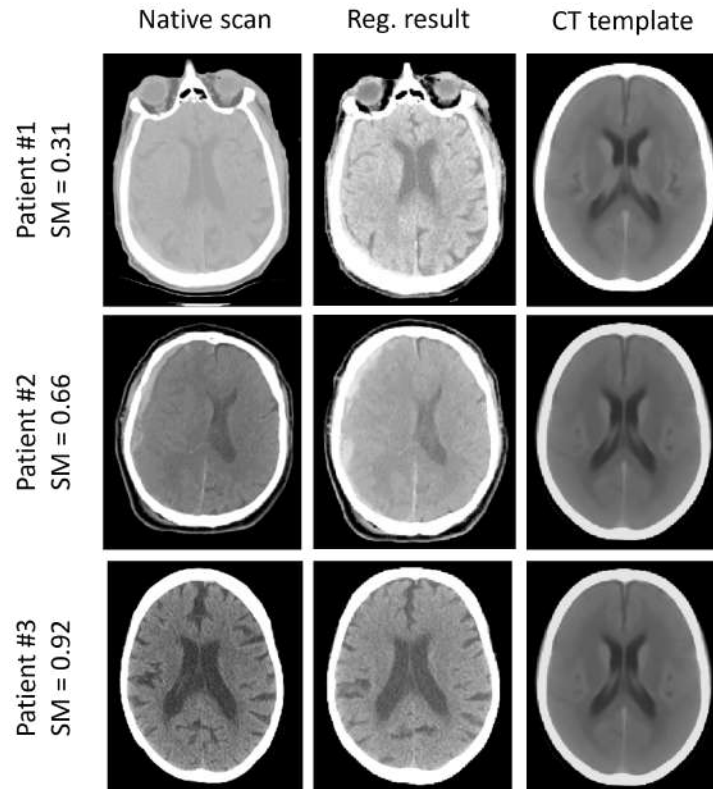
Three qualitative registration results from Dataset 2. Affine registration of native scans to the study-specific CT template.
